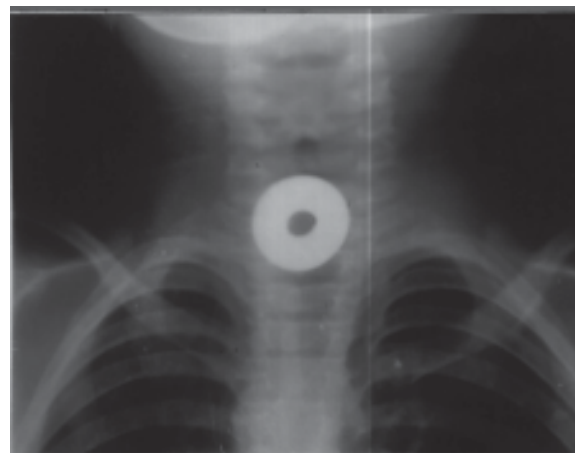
X-ray Neck posterior-anterior view showing metallic F.B, upper end of oesophagus
